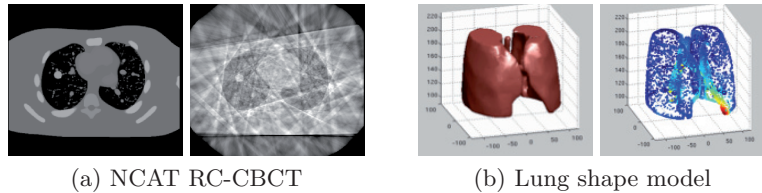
a) An axial slice of a NCAT RCCT image at EE phase and its corresponding RC-CBCT image. b) The surface mesh representation of the shape of lungs extracted from NCAT RCCTs. The color shows the magnitude of the spatial variation of each point during the breathing cycle.
